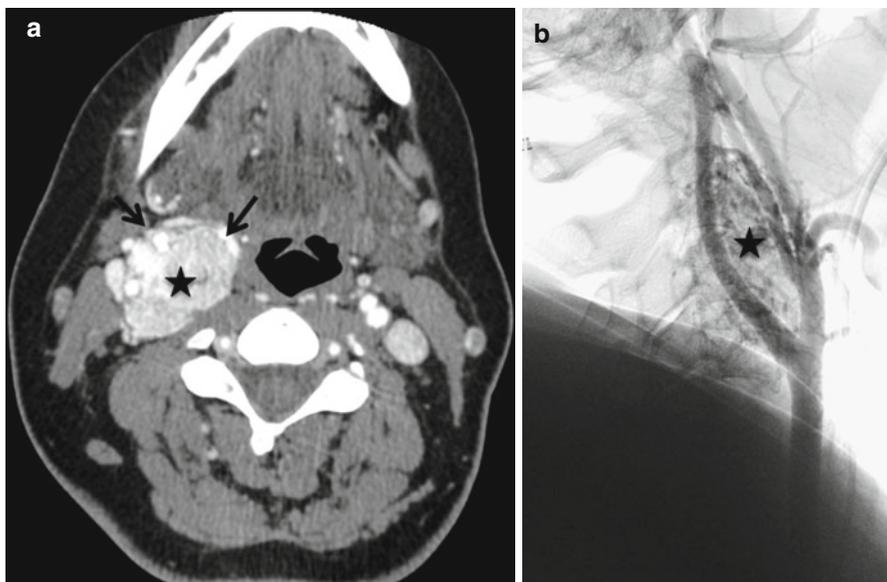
Carotid body tumor. Axial CT (a) and catheter angiogram (b) demonstrate the intense enhancement along with the hypervascular blush of this lesion within the right carotid space (*black star*). The lesion splays the carotid vessels (*small arrows*) and completely effaces the right parapharyngeal fat which is displaced anteriorly
